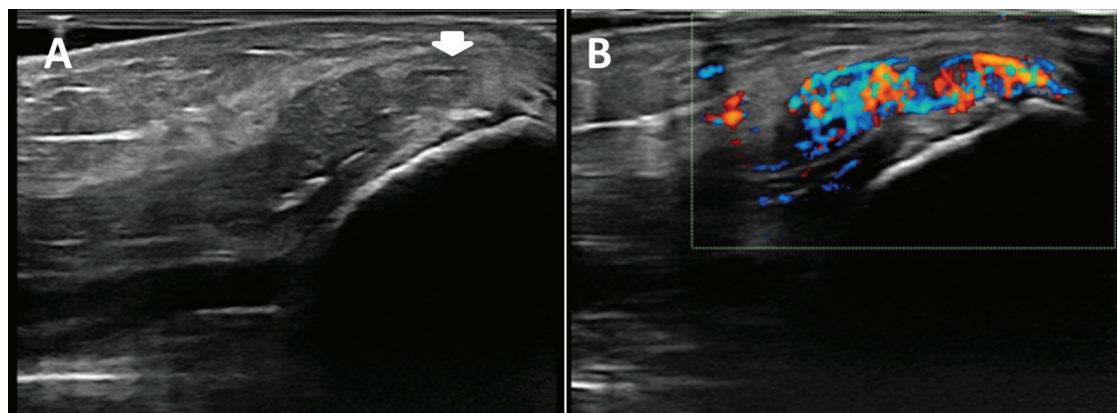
A, B. (A) Triceps tendon enthesis of the elbow with adjacent tophus in grayscale (arrow). (B) In the color Doppler image, an intense Doppler signal is observed in the tophus. The patient did not report symptoms in the elbow.
